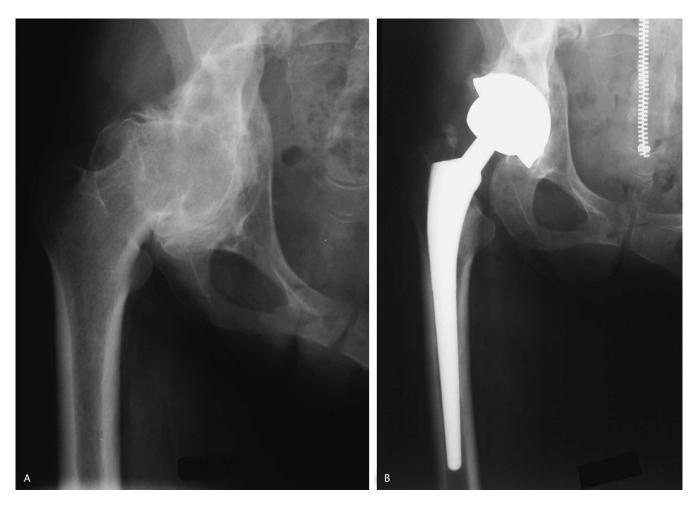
(A) An AP radiograph of the right hip of a 44-year-old woman who presented with severe pain and difficulty walking related to posttraumatic arthritis after pelvic fracture treated without fixation is shown. Her right limb was shorter than the left by 8 cm. (B) A radiograph of the same hip 1 year after the patient had cementless primary THA on the right hip using the anterolateral approach with an Mallory-Head Porous femoral component (Biomet) and M²a-38 acetabular component shows satisfactory position and alignment. Her leg-length discrepancy has been reduced and she is pain free with excellent functional capability.
